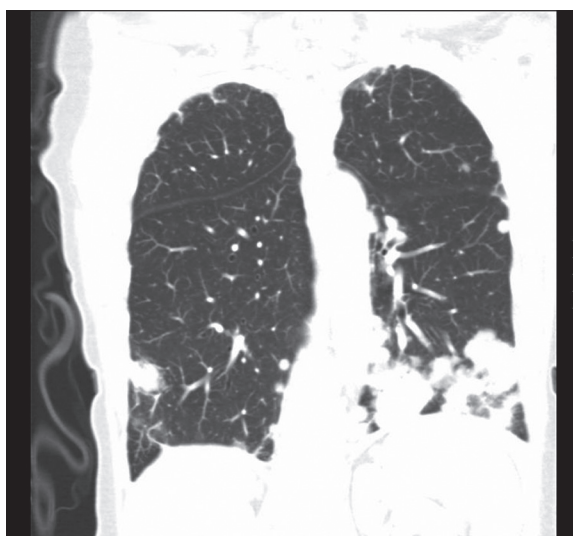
Chest CT. Multilobar pneumonia.
